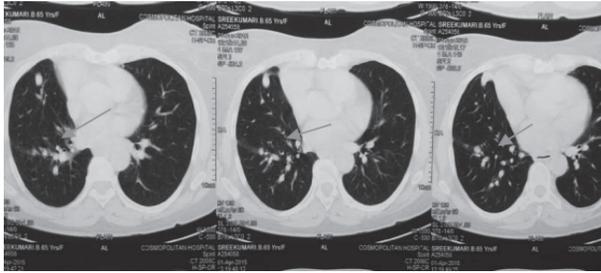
CT thorax showing a well defined lesion near the right cardiophrenic angle.
